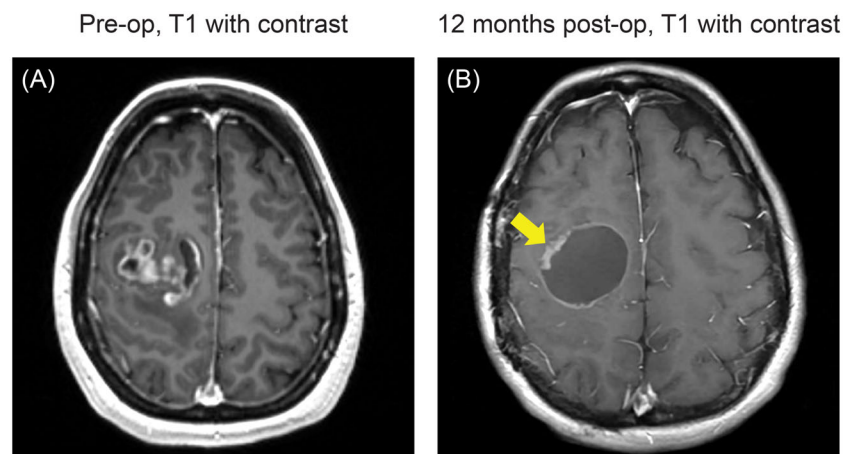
Imaging features. Preoperative magnetic resonance imaging (A) demonstrated a heterogeneously enhancing lesion in the right posterior frontal lobe. Postoperative imaging demonstrated near gross total resection, but 6- and 12-month follow-up imaging (B) demonstrated tumor recurrence/progression (arrow).
